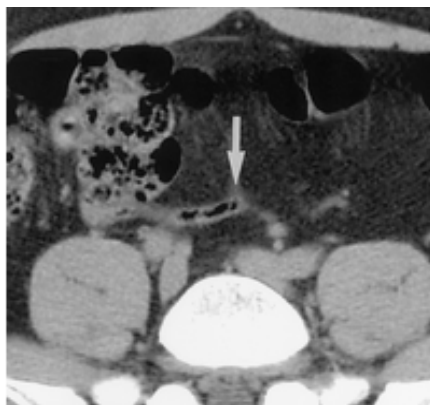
a& b): Transverse non enhanced helical CT scans of the abdomen in two patients. (a) The thickness of the wall of the appendix without content is measured by means of subtracting the thickness of air content (arrowheads) from the full thickness (straight arrows). (b) The full thickness of the appendix (arrows) is measured, since the content is not recognizable. This appendix is 8 mm thick (*Benjaminov et al., 2012*).
